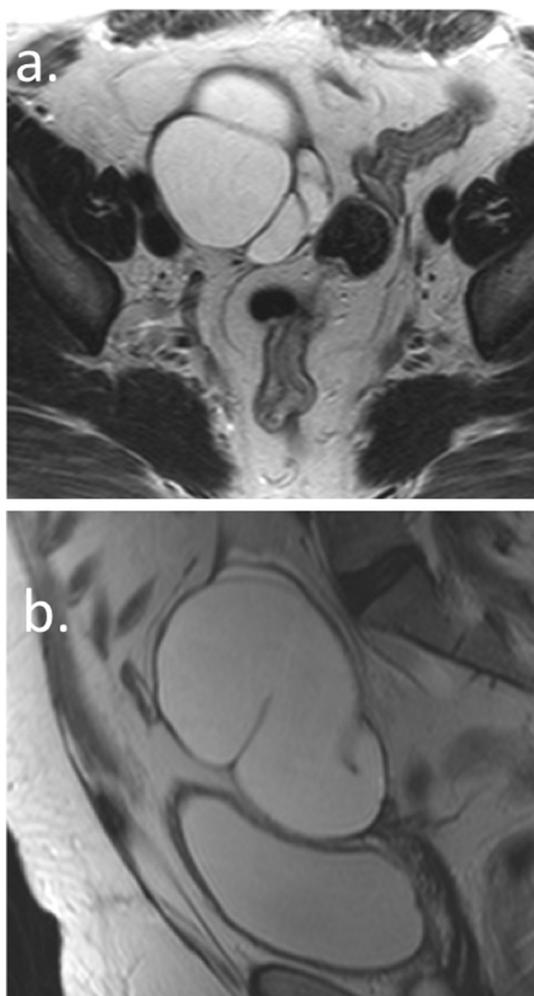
Utility of multiple planes of T2-weighted imaging in the diagnosis of hydrosalpinx when evaluating a cystic adnexal lesion on MRI. (a) T2-weighted axial and (b) T2-weighted right paramedian sagittal reveal a tubular cystic structure in keeping with hydrosalpinx.
